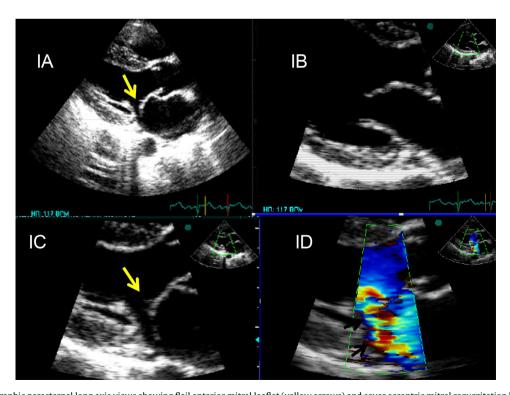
2D echocardiographic parasternal long axis views showing flail anterior mitral leaflet (yellow arrows) and sever eccentric mitral regurgitation by color Doppler (black arrows, ID).
